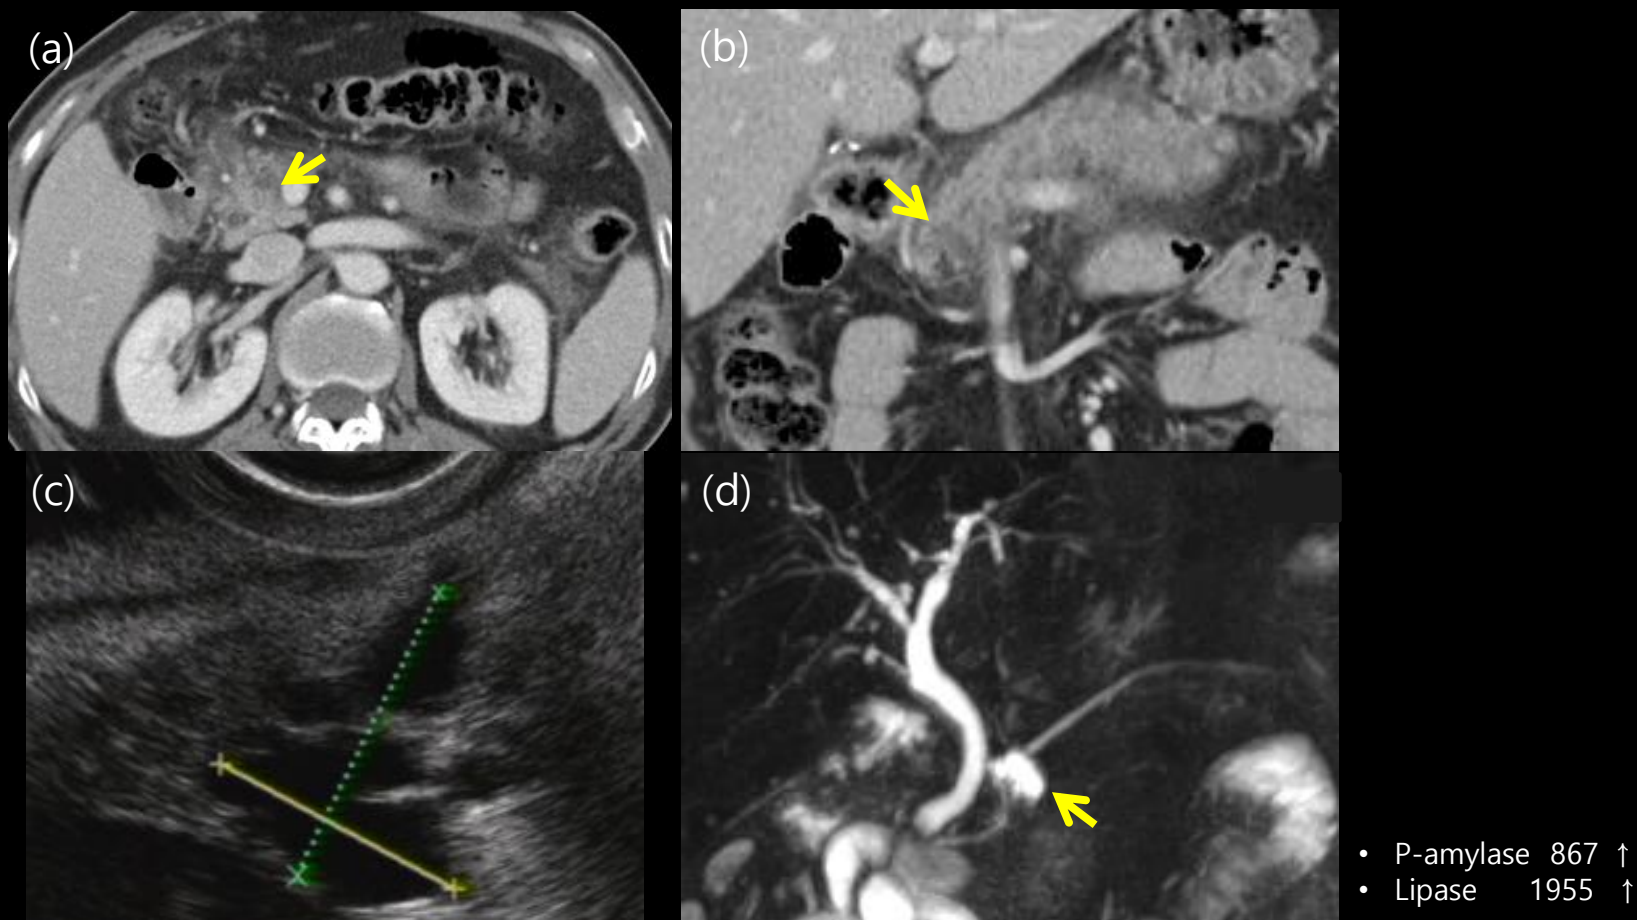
62 years old man presented with recurrent pancreatitis by benign IPMN. (a), (b) Axial contrast material-enhanced abdomen CT images & coronal oblique reconstructed image show diffuse pancreatic swelling with peripancreatic infiltration, fluid collection and cystic lesion in pancreatic head. (yellow arrow) The lesion didn't exist in previously performed contrast-enhanced abdomen CT for about 4 months. (c) In endoscopic ultrasonography, multilocular anechoic lesion (yellow arrow) with internal echogenic material is detected. (d) MRCP depicts multi-septated cystic lesion communicated with pancreatic duct in pancreatic head. (yellow arrow) Main pancreatic duct is not dilated.
